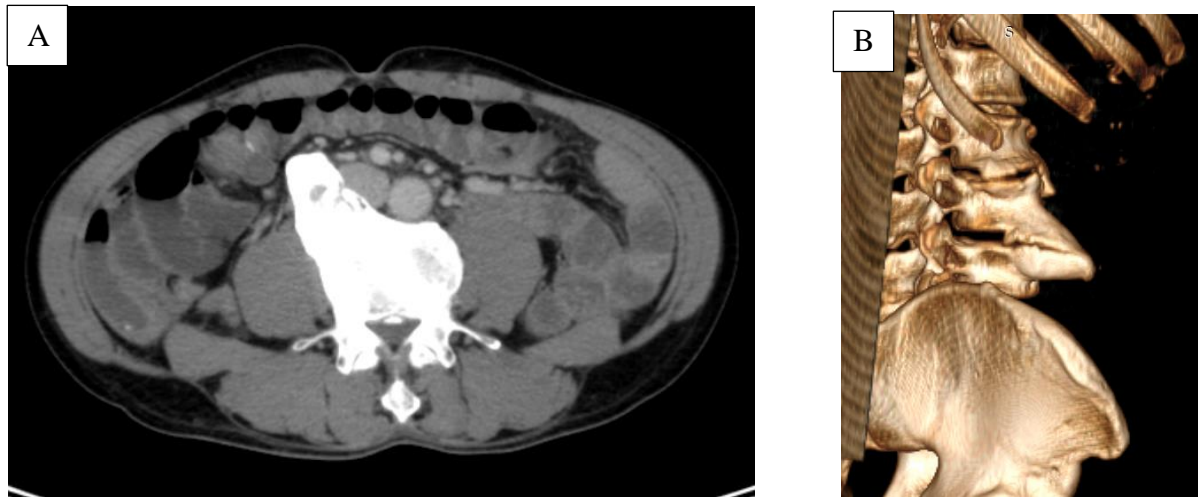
CT aspect of the osteophyte (A: axial section, B: 3D reconstruction)
